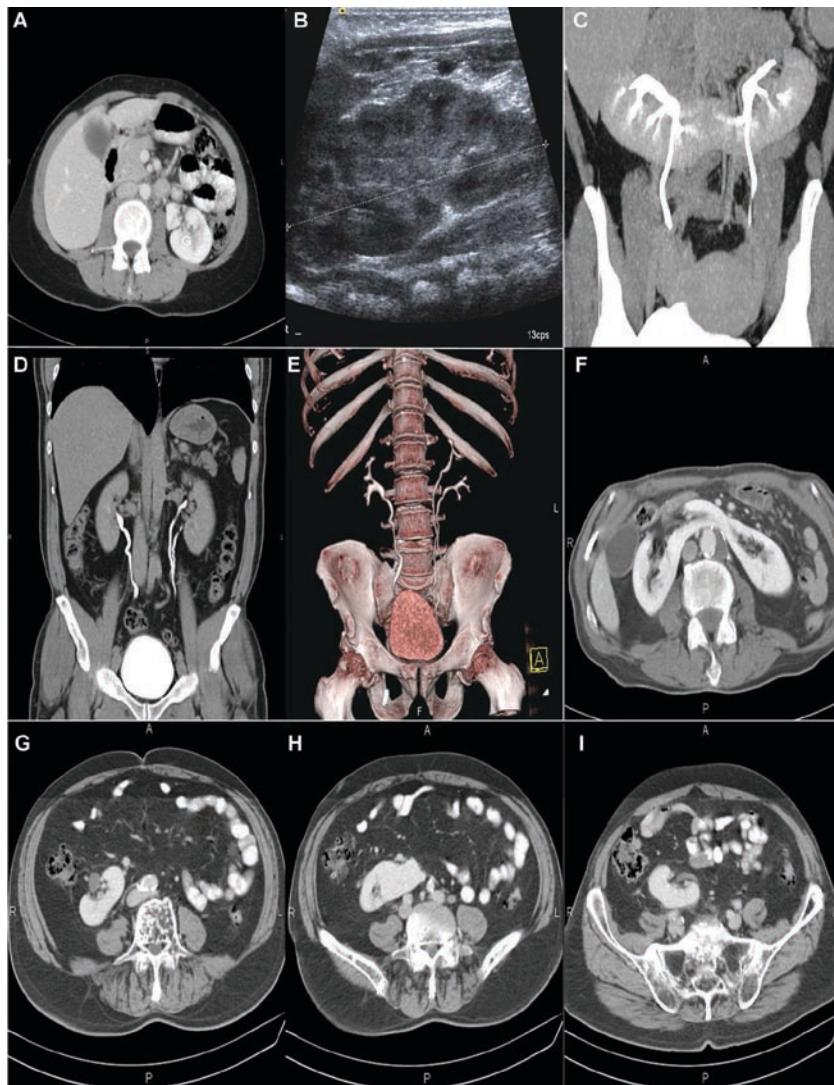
Main renal malformations associated with Turner's syndrome. (A) Axial plane of an abdominal TC showing a right renal agenesis. (B) Abdominal ultrasound showing a compensatory right renal hypertrophy in a newborn with unilateral agenesis. (C) Coronal CT-urography reconstruction showing a horseshoe kidney. (D) & (E) Coronal CT-urography reconstructions showing a duplex system of the left kidney. (F) Axial plane of a CT showing a horseshoe kidney. (G), (H) & (I) Three different axial CT planes of the same patient showing renal malposition, being both kidneys on the right side.
